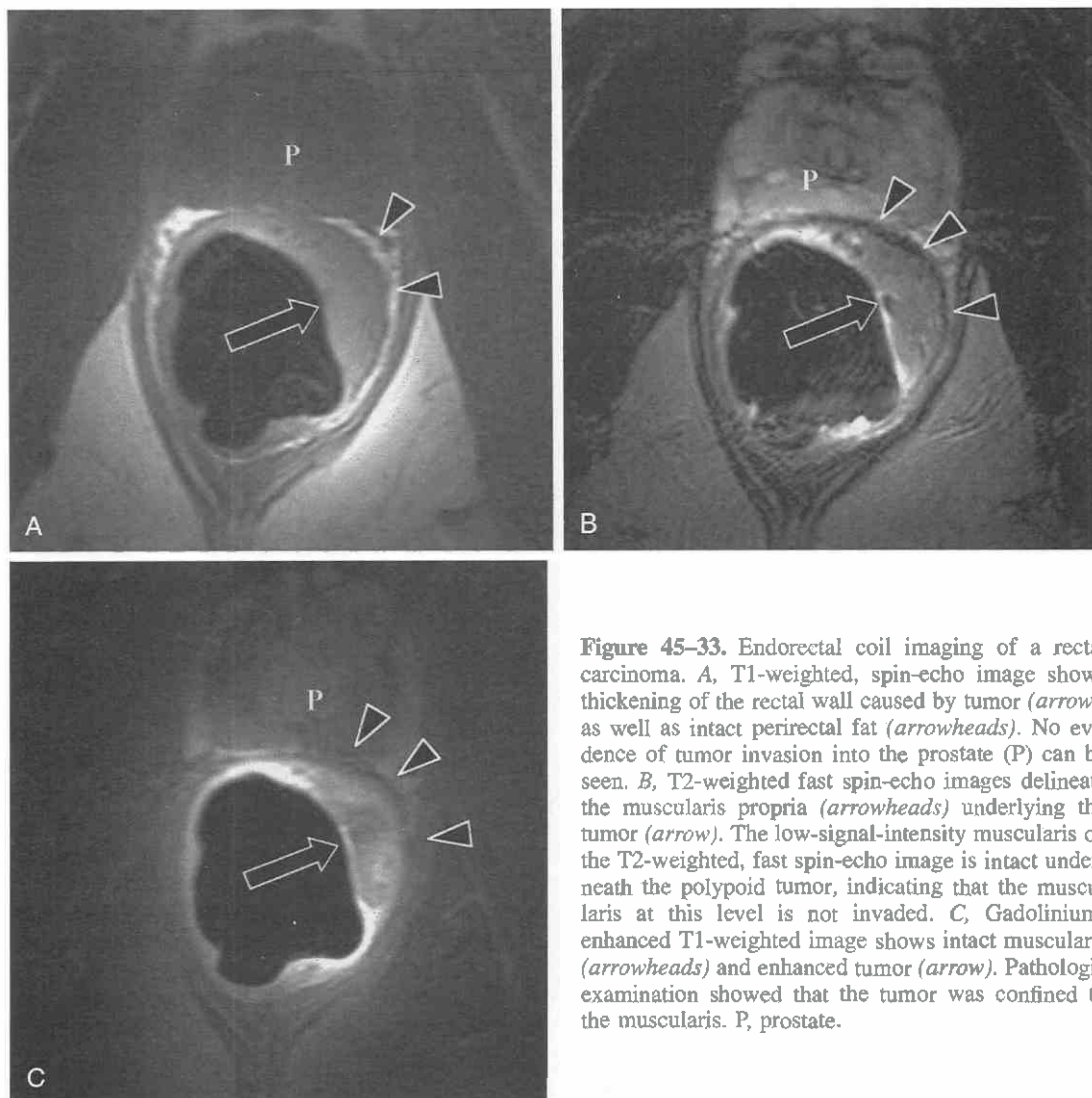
Endorectal coil imaging of a rectal carcinoma. *A*, T1-weighted, spin-echo image shows thickening of the rectal wall caused by tumor (arrow), as well as intact perirectal fat (arrowheads). No evidence of tumor invasion into the prostate (P) can be seen. *B*, T2-weighted fast spin-echo images delineate the muscularis propria (arrowheads) underlying the tumor (arrow). The low-signal-intensity muscularis on the T2-weighted, fast spin-echo image is intact underneath the polypoid tumor, indicating that the muscularis at this level is not invaded. *C*, Gadolinium-enhanced T1-weighted image shows intact muscularis (arrowheads) and enhanced tumor (arrow). Pathologic examination showed that the tumor was confined to the muscularis. P, prostate.
